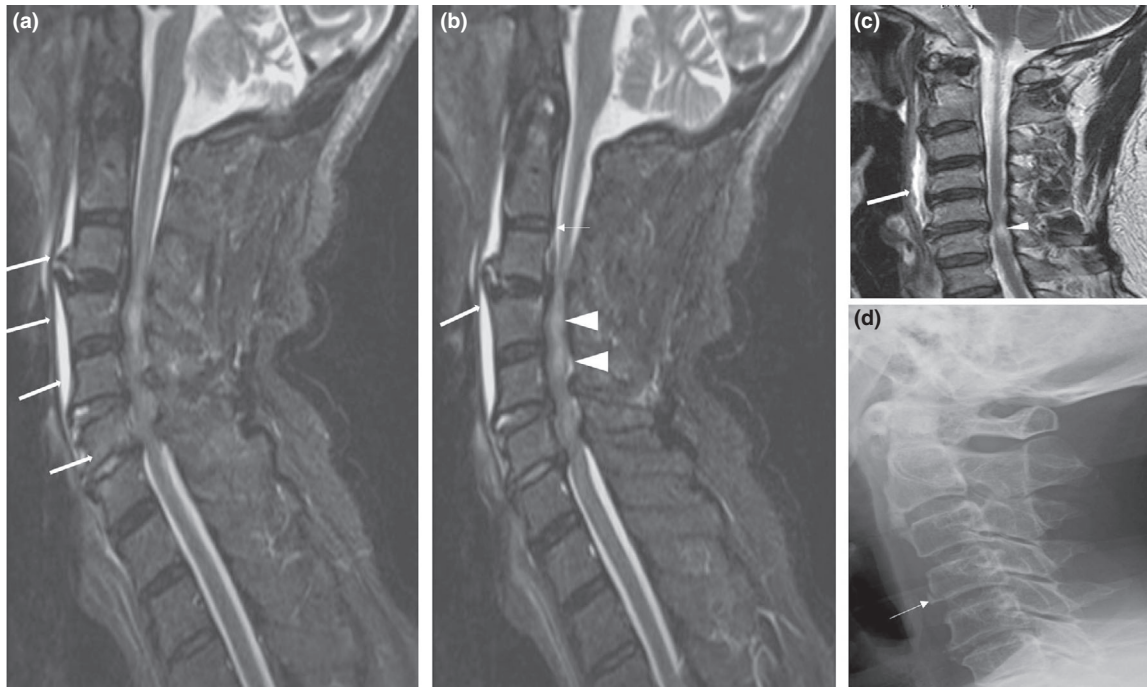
Hyperextension injury in a 70-year-old man. (a) and (b) contiguous sagittal STIR MR images show the most prominent finding of fluid lifting the ALL at C3/4, C5/6, C6/7 (thick arrows) implying anterior disc/ALL tears at these levels. The ALL is seen discontinuous from C6 to T1 levels. Also seen are partial PLL tear at C3 (thin arrow) and central cord syndrome with intramedullary cord hyperintensity (arrowheads). An acutely injured ALL/ PLL is easily identified by increased T2/ STIR signal, stripping of the ligament by fluid or haemorrhage or discontinuity. Disc injuries are identifiable as STIR hyperintense oedema associated with either widening or narrowing of the disc space. (c) Sagittal T2W MR image in hyperextension injury in a different patient shows ALL tear from C2-6 levels with fluid (thick arrow). A focal cord contusion (arrowhead) is also depicted at C5/6 level (d) lateral radiograph shows a C4 corner fracture (thin arrow) which is difficult to detect on MRI. ALL injury maybe associated with anterior endplate avulsion fractures and it is advisable to correlate MRI findings with either a CT/ radiographs.
